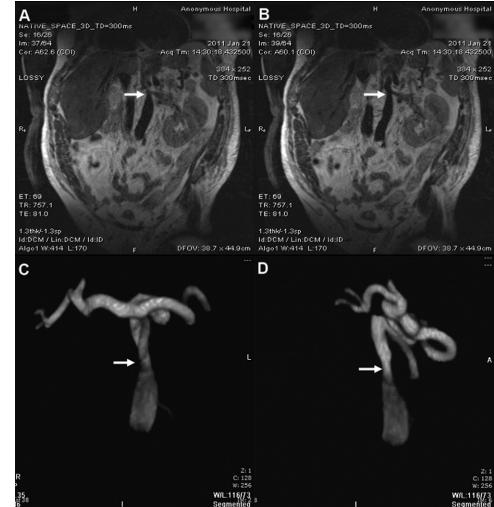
Magnetic resonance images show (A, B) narrowing of the abdominal aorta (arrows). (C, D) Also note the narrowing of the abdominal aorta (arrows), consistent with midaortic syndrome. Download English Version:
